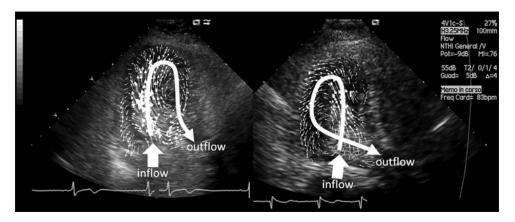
Echocardiographic visualization of the left ventricle (shown upside-down in the pictures) in a normal subject (left) and in a subject with mechanical mitral valve (right). Images are taken during the final stage of the flow entrance (end-diastole), the estimated velocity vectors are superimposed, and the qualitative flow path is sketched with the thick line.
